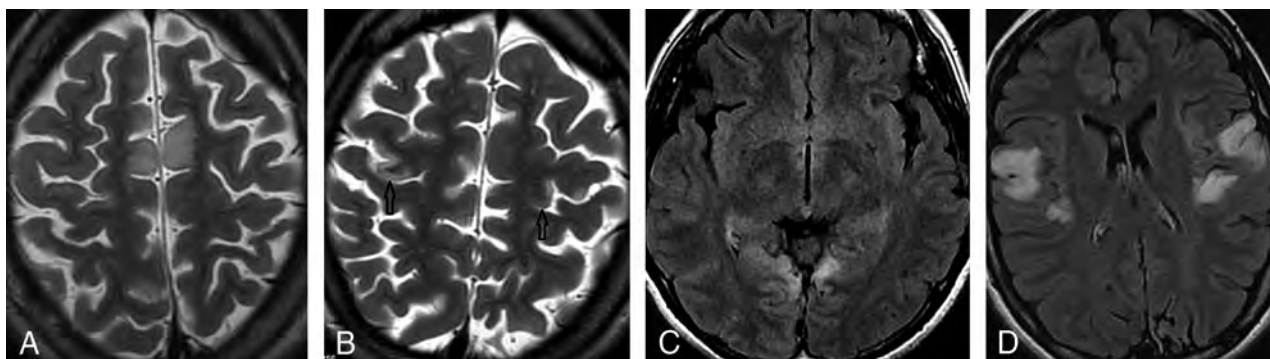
Axial MR imaging shows 4 examples of symmetric cortical involvement by acute lesions in patients with MELAS. A, T2-weighted spin-echo image shows symmetric hyperintense signal in the deep cortex and juxtacortical white matter of the bilateral medial frontal gyri, with sparing of the superficial cortex (typical for pseudolaminar involvement). B, T2-weighted spin-echo image shows symmetric hyperintense intracortical signal in the middle-thirds (black arrows) of the bilateral precentral gyri (hand regions of the primary motor cortex), with sparing of the superficial cortex. C, T2-FLAIR image shows symmetric cortical and subcortical hyperintense signal in the pericalcarine cortex of the bilateral medial occipital lobes (primary visual cortex). D, T2-FLAIR image shows symmetric cortical and subcortical hyperintense signal in the posterior halves of the bilateral superior temporal gyri (primary auditory cortex).
